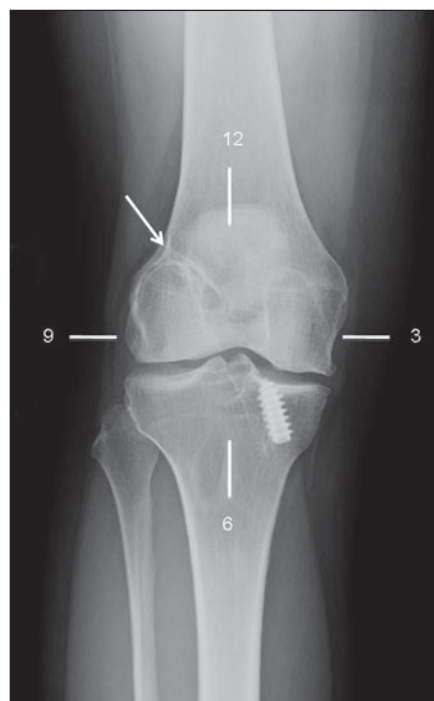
Anteroposterior radiograph of 21-year-old man who presented for follow-up evaluation after reconstruction of right anterior cruciate ligament using doubled semitendinosus and gracilis tendon graft. Endobutton (Smith & Nephew) fixation device is seen at superior aspect of femoral tunnel.
